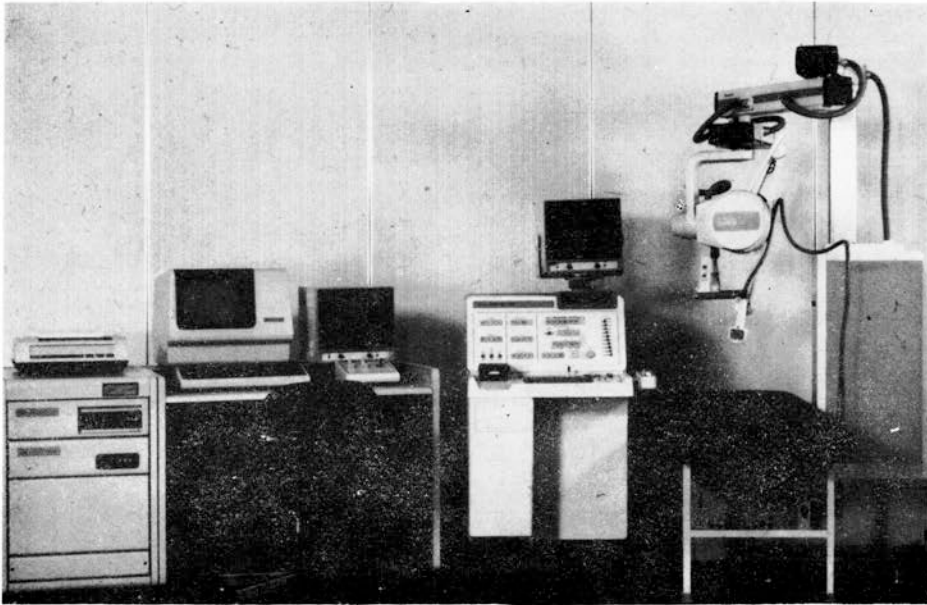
Outlook of the systems, which we used in measuring the ultrasonic attenuation coefficients.
